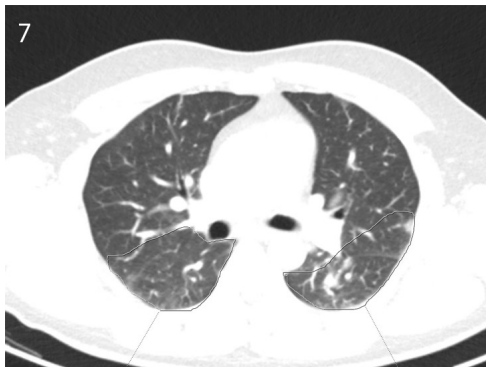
The same patient as in Figure 5. Initial dual-energy computed tomography images. Consolidation-related perfusion deficits are marked.
